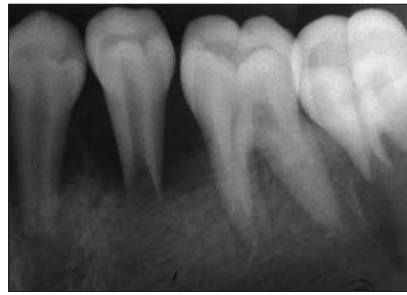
Periapical radiograph showing severe alveolar bone resorption around the lower second premolars.
